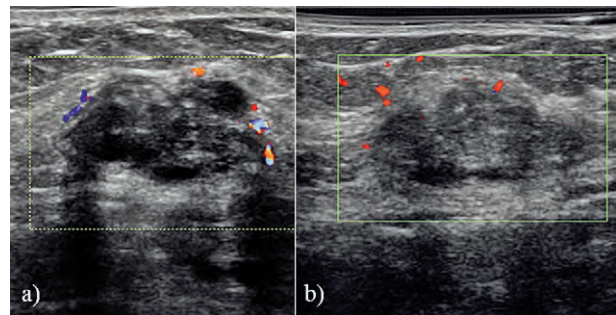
Color Doppler US images showing peripheral flow within the mass (a and b).
